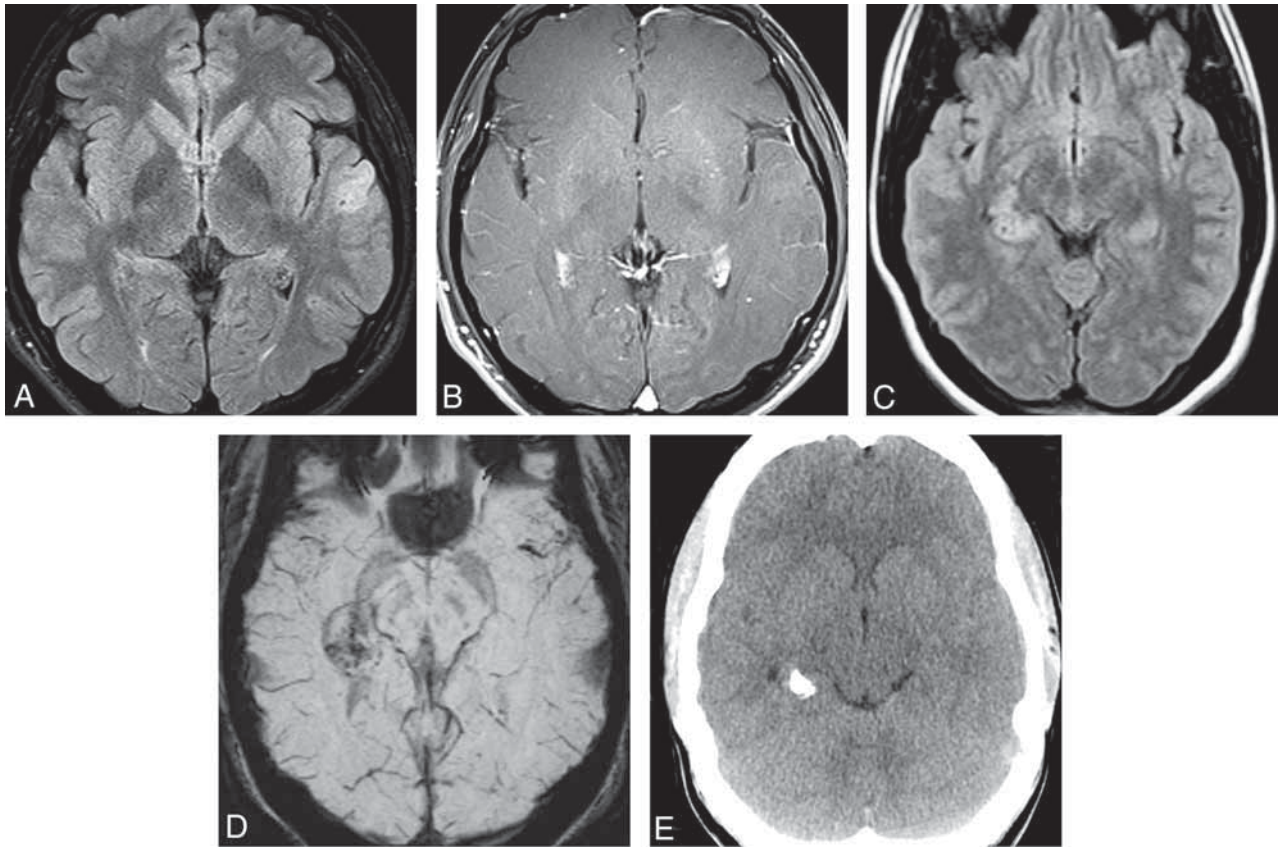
Two patients with the WHO 2021 new-entity polymorphous low-grade neuroepithelial tumor of the young (PLNTY). Axial FLAIR (A) and postcontrast T1-weighted (B) MR images in a 19-year-old man with refractory epilepsy show a hyperintense, nonenhancing mass in the cortex and subcortical white matter of the left temporal lobe. Axial FLAIR (C) and susceptibility-weighted (D) MR images and a noncontrast CT image (E) in a 19-year-old woman with progressive seizure show a FLAIR-hyperintense, SWI-hypointense mass with characteristic calcification seen on CT in the right medial temporal lobe (Case courtesy of M. Castillo, MD).
